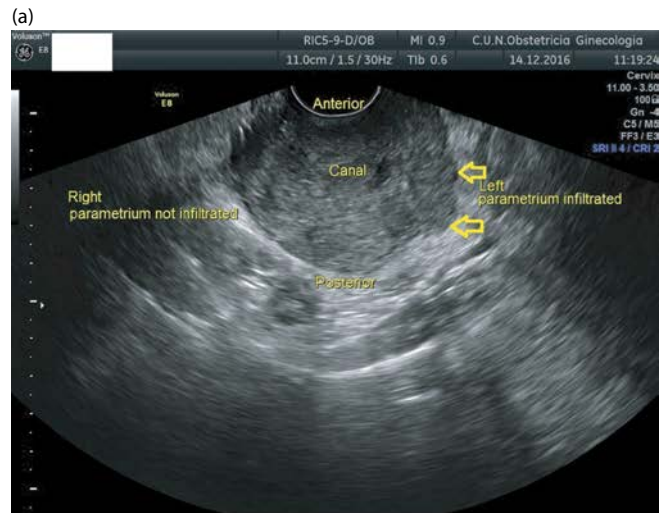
Transverse view of the cervix by transvaginal ultrasound. This view allows the assessment of parametrial infiltration. Case (a) shows how the left parametrium is infiltrated. The cervical contour is irregular as the tumor infiltrates the proximal parametrium (arrows). When the borders of the cervix remain smooth (arrows), no infiltration is suggested (b). In case (c), there is an infiltration of the right parametrium.
